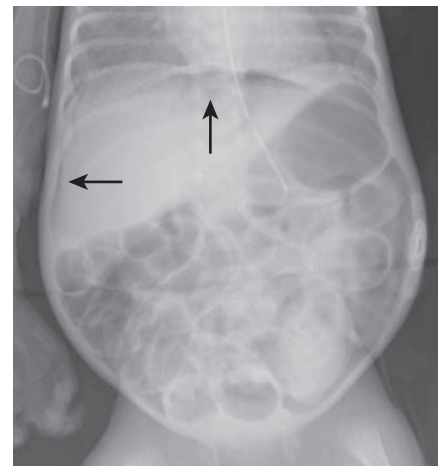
Free air (arrows) is seen on this radiograph. This finding is an indication of perforation and is considered an absolute indication for intervention, whether drainage or exploration.
